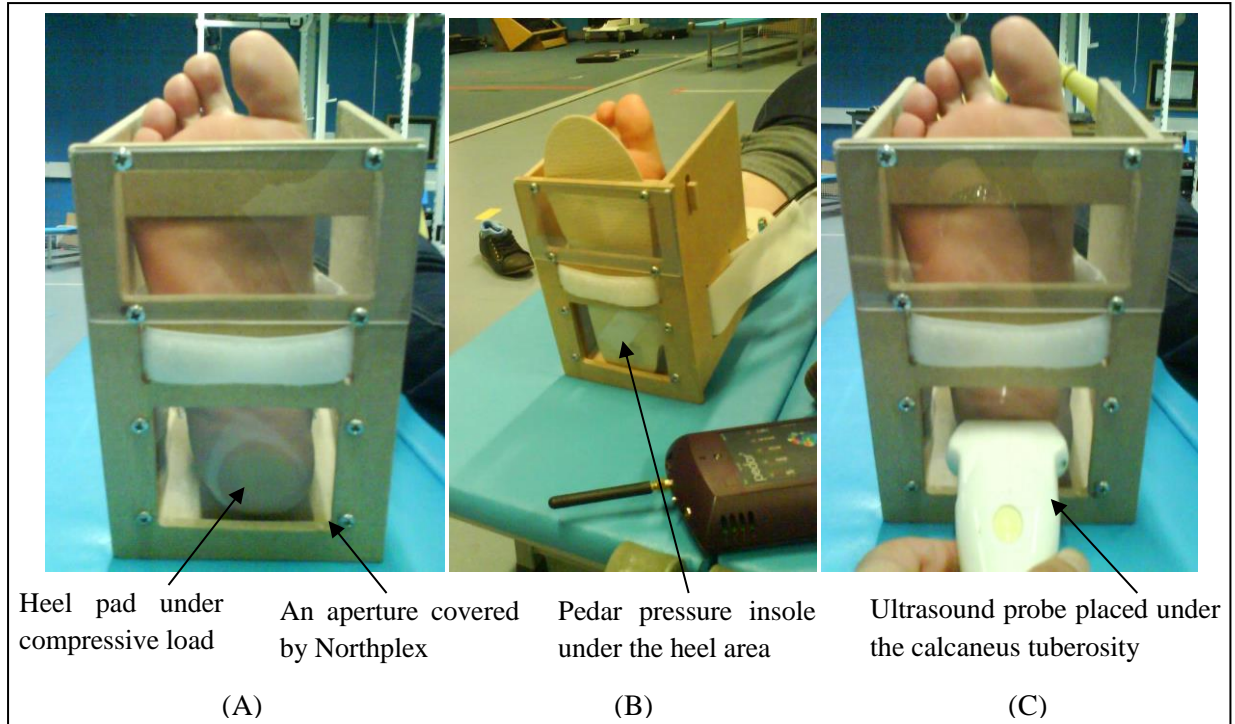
measuring loaded thickness of the heel pad under specific load: (A) Applying compression load under the heel pad using the loading device; (B) Measuring the compressive load using the Pedar pressure insole; (C) Measuring the loaded thickness of the heel pad using the ultrasound modality.
